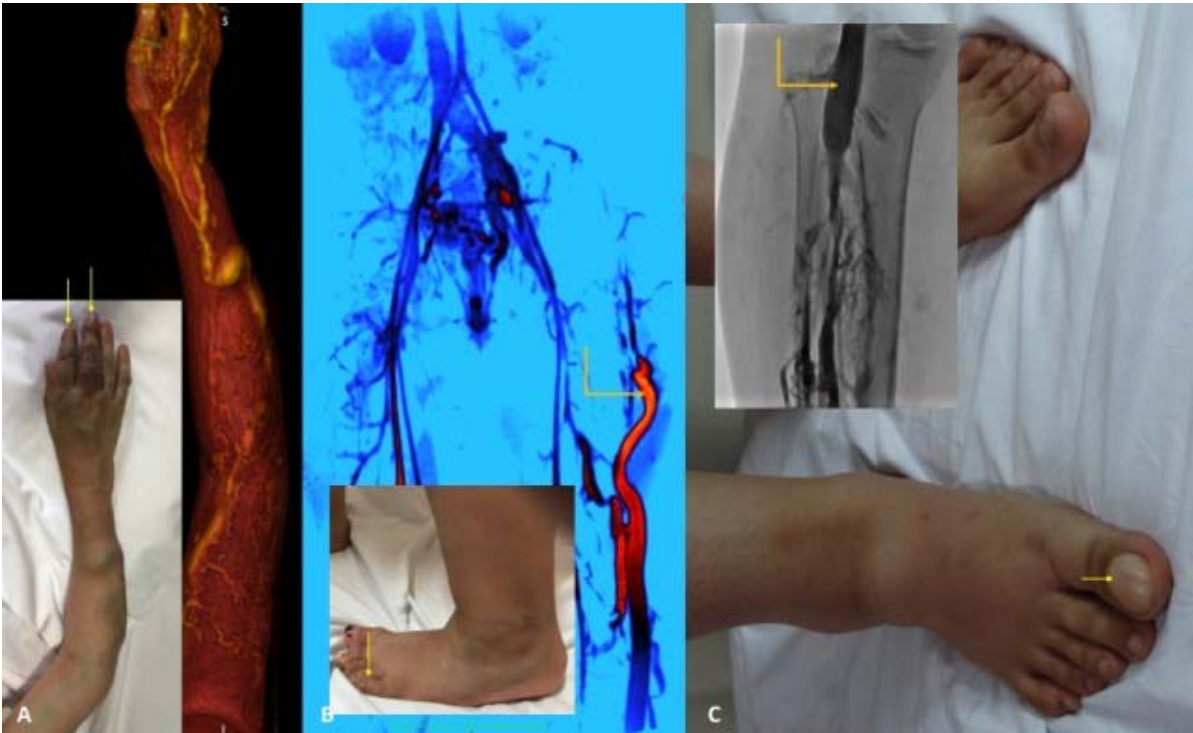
Clubbing in a patient with truncular venous malformation (T-VM) (arrows) (A). Clubbing in a patient with lower extremity VM (arrow); a CT venography showing an embryonic lateral mega vein (elbow-arrow) (B). Hallucal clubbing in a patient with lower limb T-VM (arrow). Note the aneurysmal dilatation of the popliteal vein in this patient (elbow-arrow) (C).
